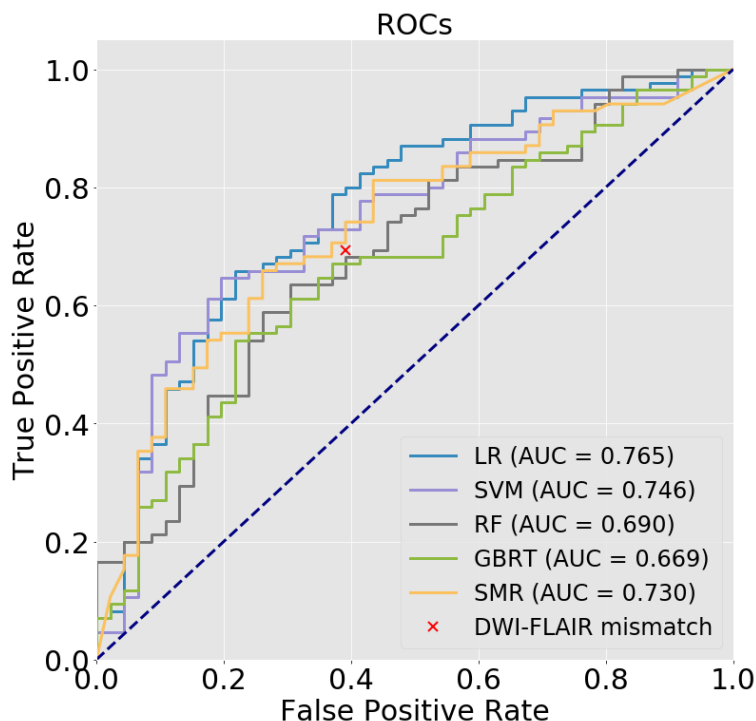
The ROCs of different classifiers trained with both the baseline imaging features and the deep features (generated from the deep AE with the AIF + contralateral coupling patch). The red cross indicated the neuroradiologist classification using the DWI-FLAIR mismatch method.
